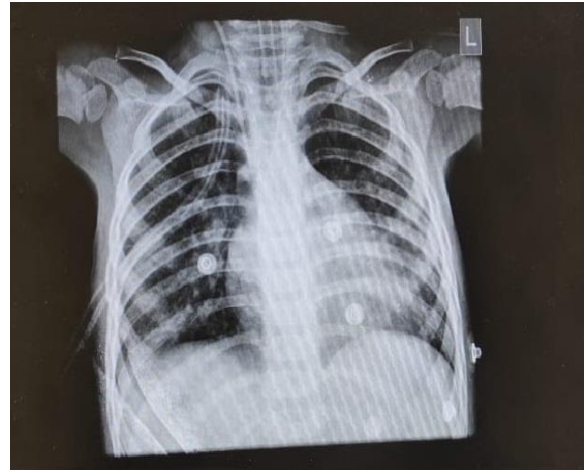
The chest X-ray after right chest tube insertion shows left ventricular and left atrial enlargement.
